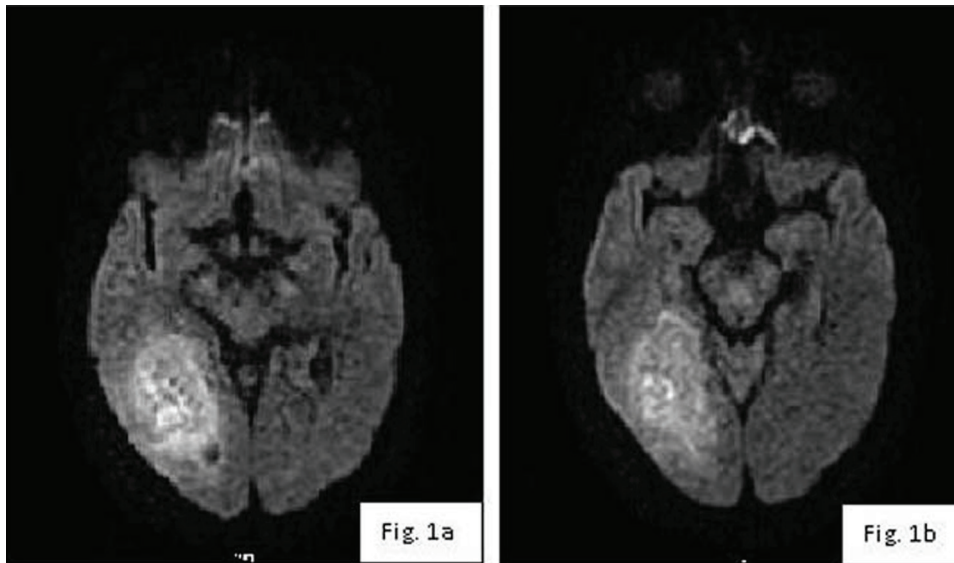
MRI of the brain prebiopsy.
